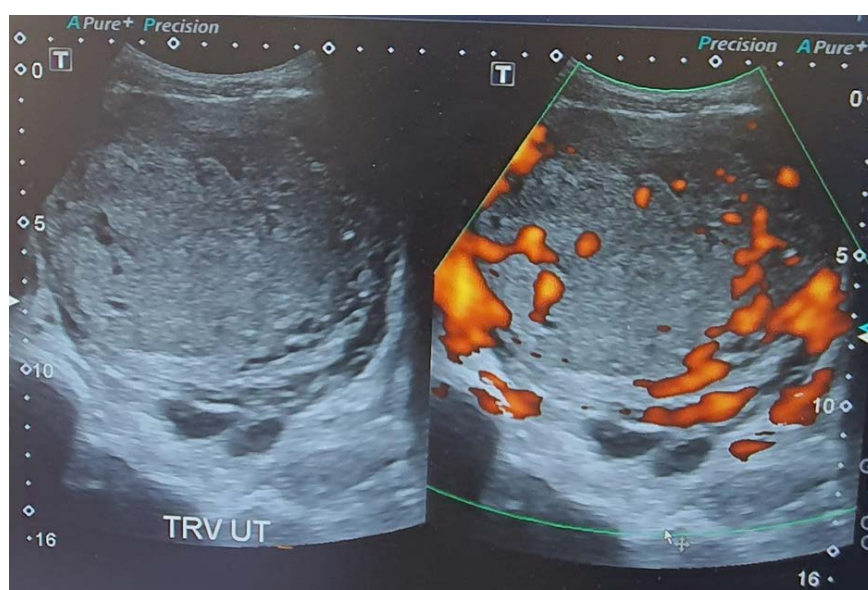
Transvaginal ultrasound showing an enlarged uterus with a honeycomb appearance and hypervascular flow seen within the mass
